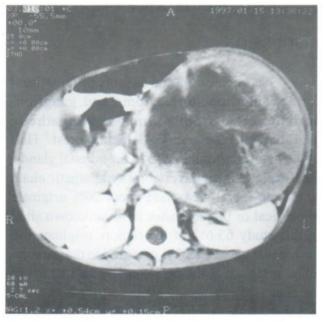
Contrast CT scan shows a well-defined inhomogeneous soft tissue mass which is pressing the anterior aspect of the left kidney. It extends across the midline but does not encase the great vessels.
